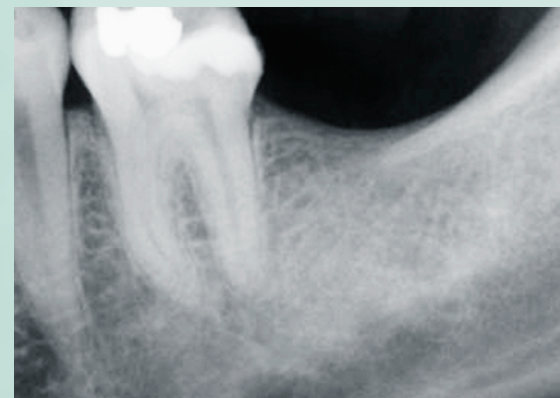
Preoperative radiograph of tooth #19(36) is indicative of a fractured distal marginal ridge with recurrent caries.
